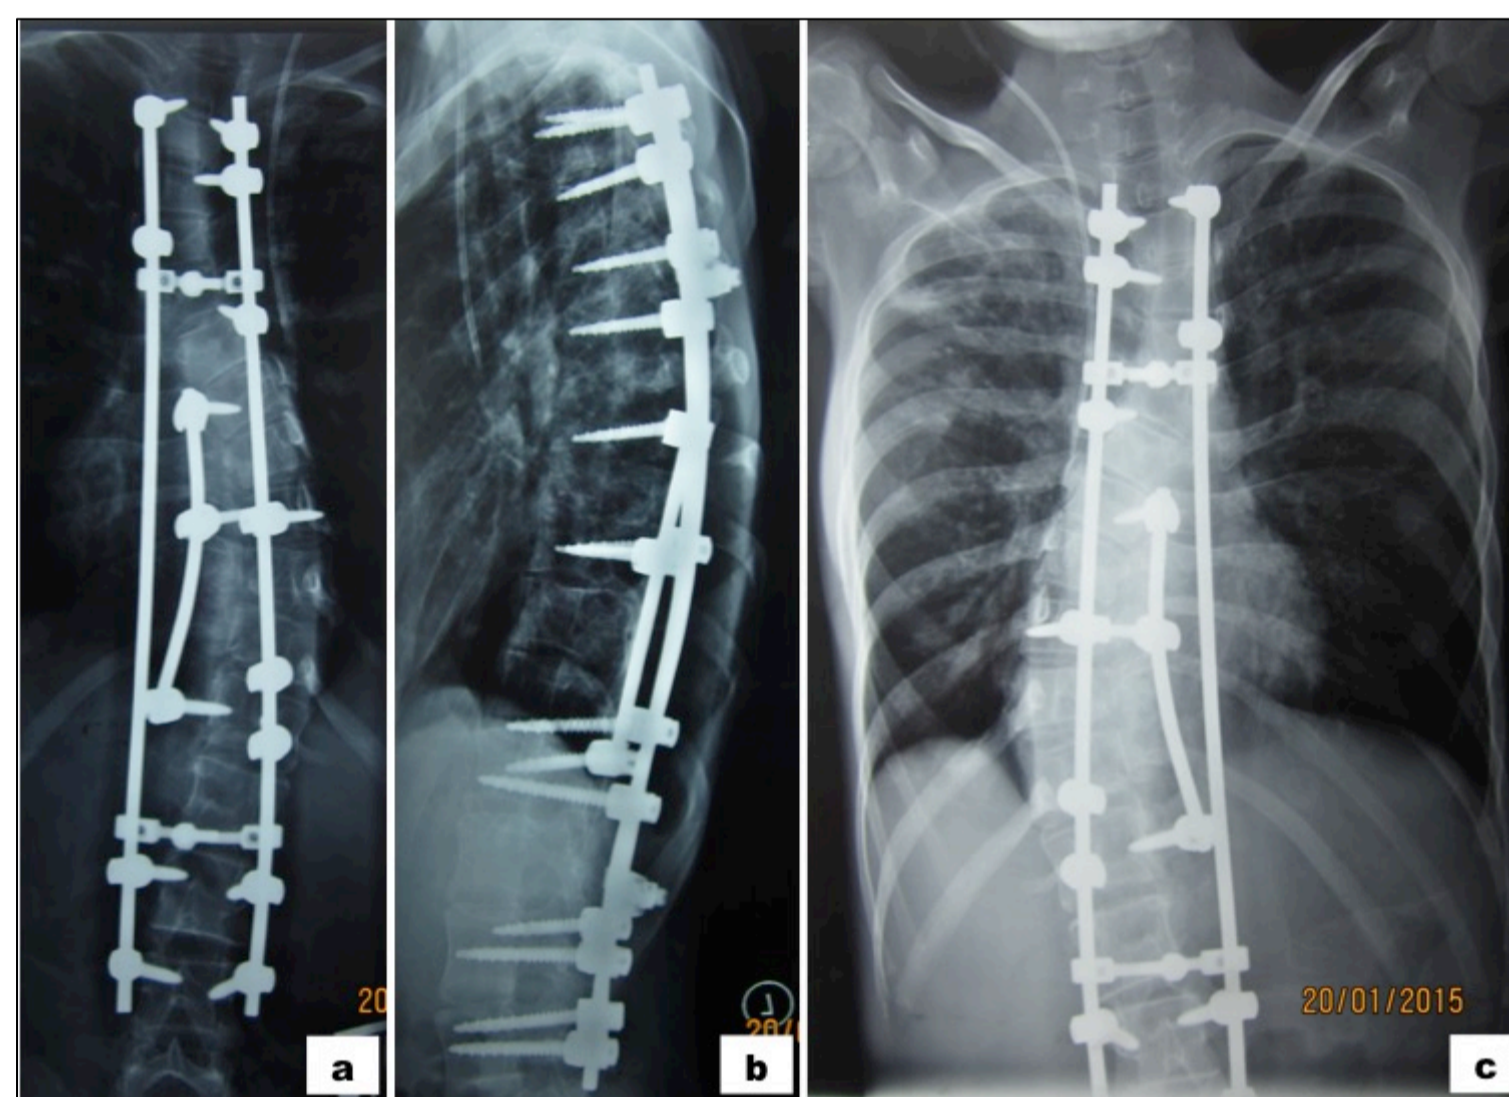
Good deformity correction was achieved (a,b). Post-operative chest radiograph (c).
